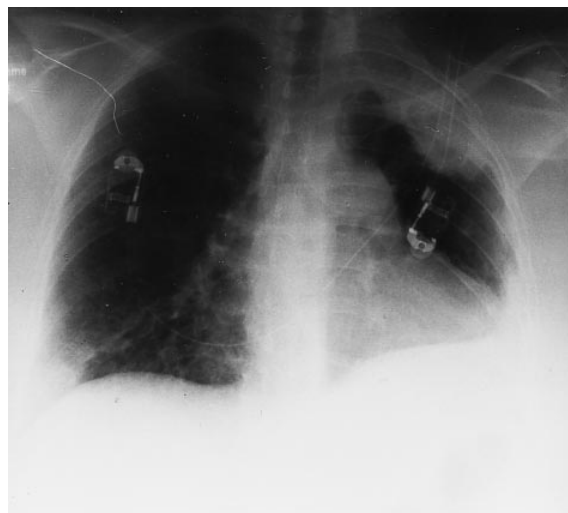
Posteroanterior chest radiograph showing peripheral wedge-shaped opacities in the left upper and right lower lobes. Left-sided pleural effusion and pulmonary arterial hypertension with fullness of the main pulmonary artery and an abrupt decrease of the caliber of peripheral branches.
